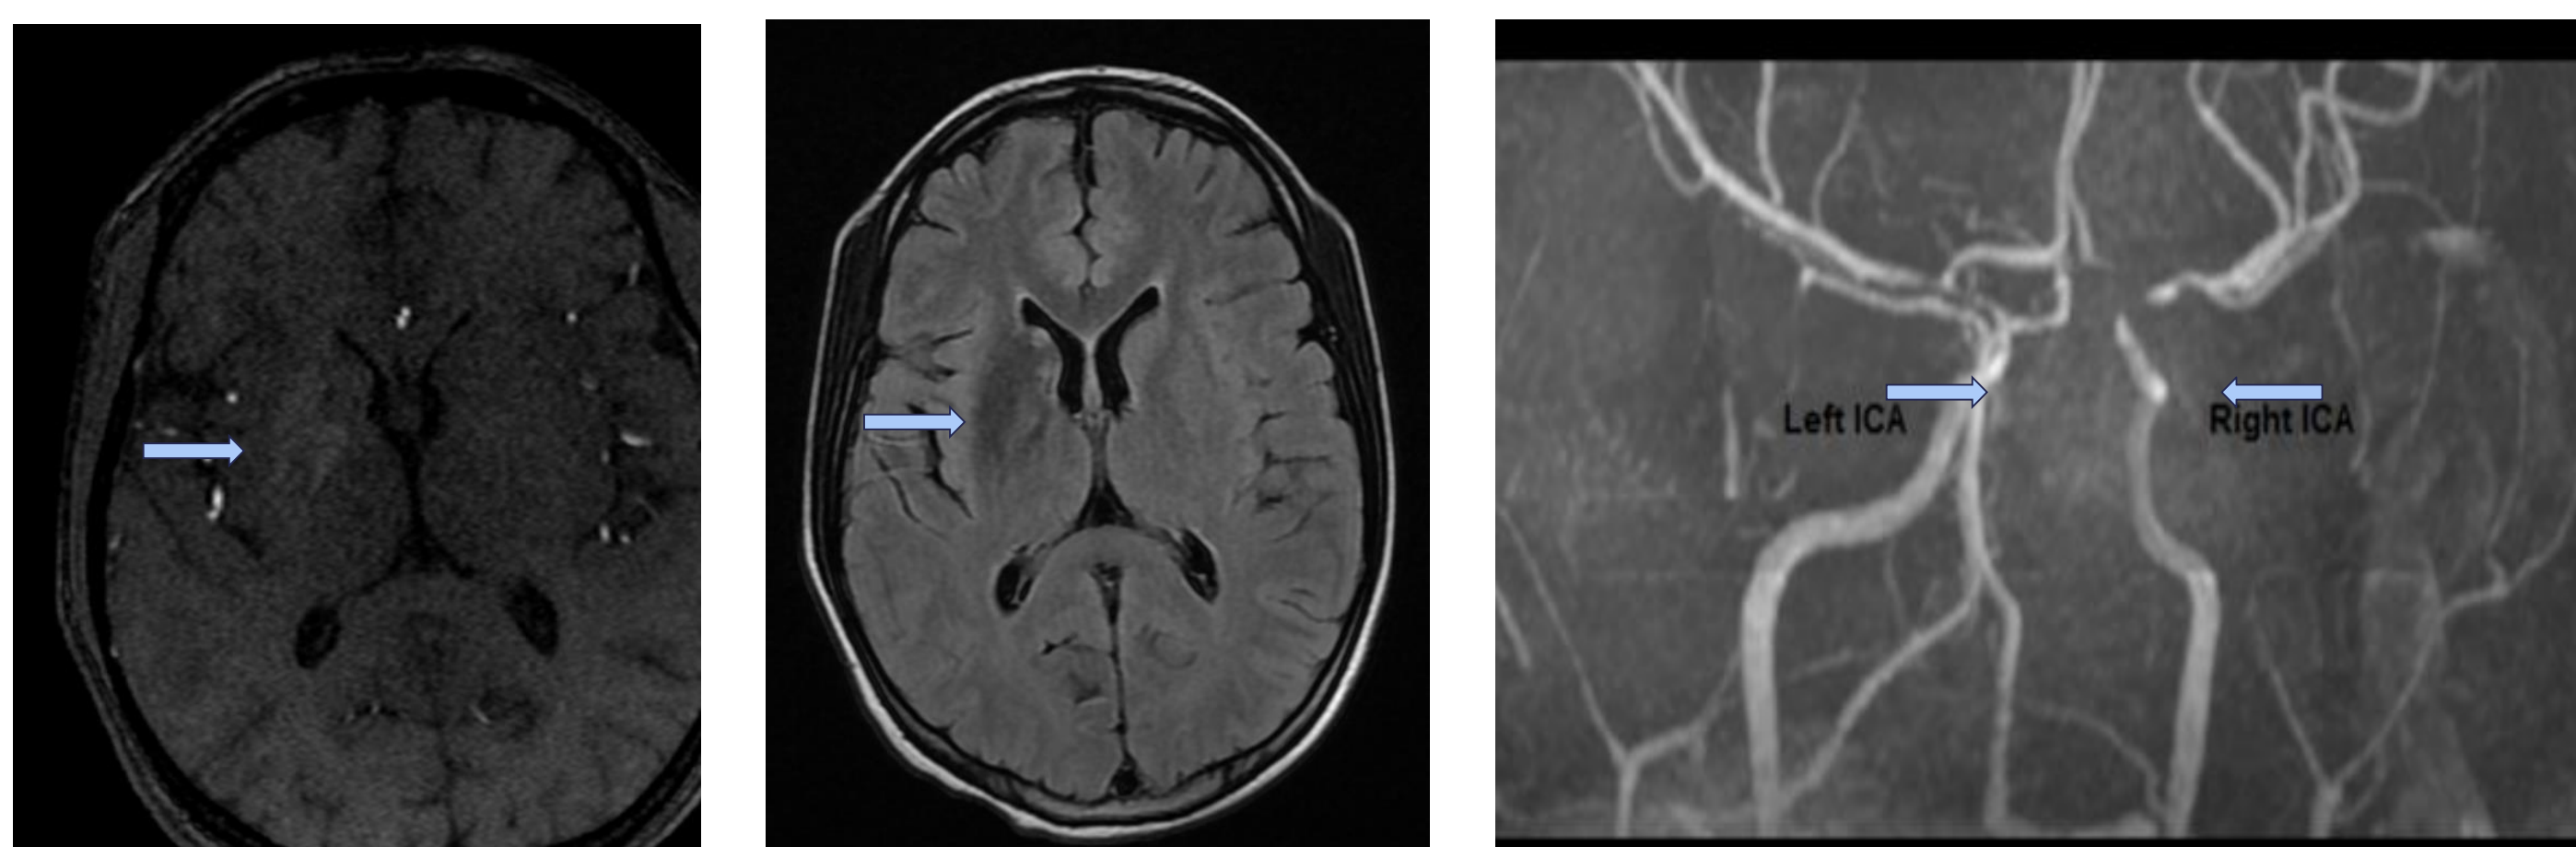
Abnormal signal in the right basal ganglia (involving both caudate nucleus and lentiform nucleus) with high T1W signal (left image) and low T2W/FLAIR signal (right image)
